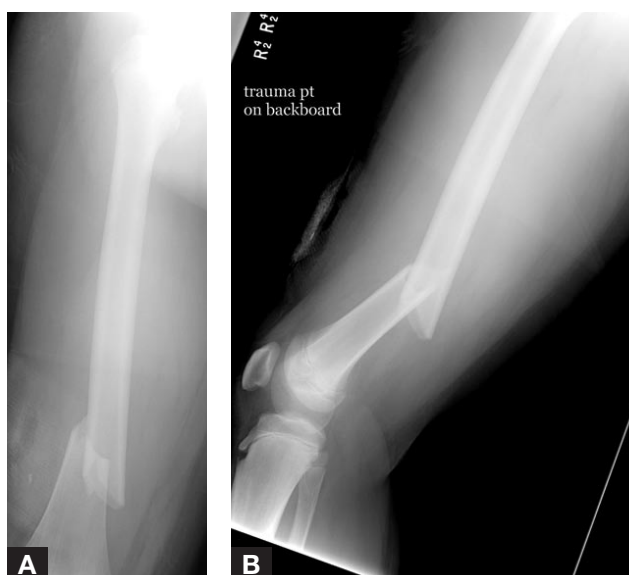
Anteroposterior (A) and lateral (B) radiographs of right distal femur show distal-third, short-oblique femur fracture.
